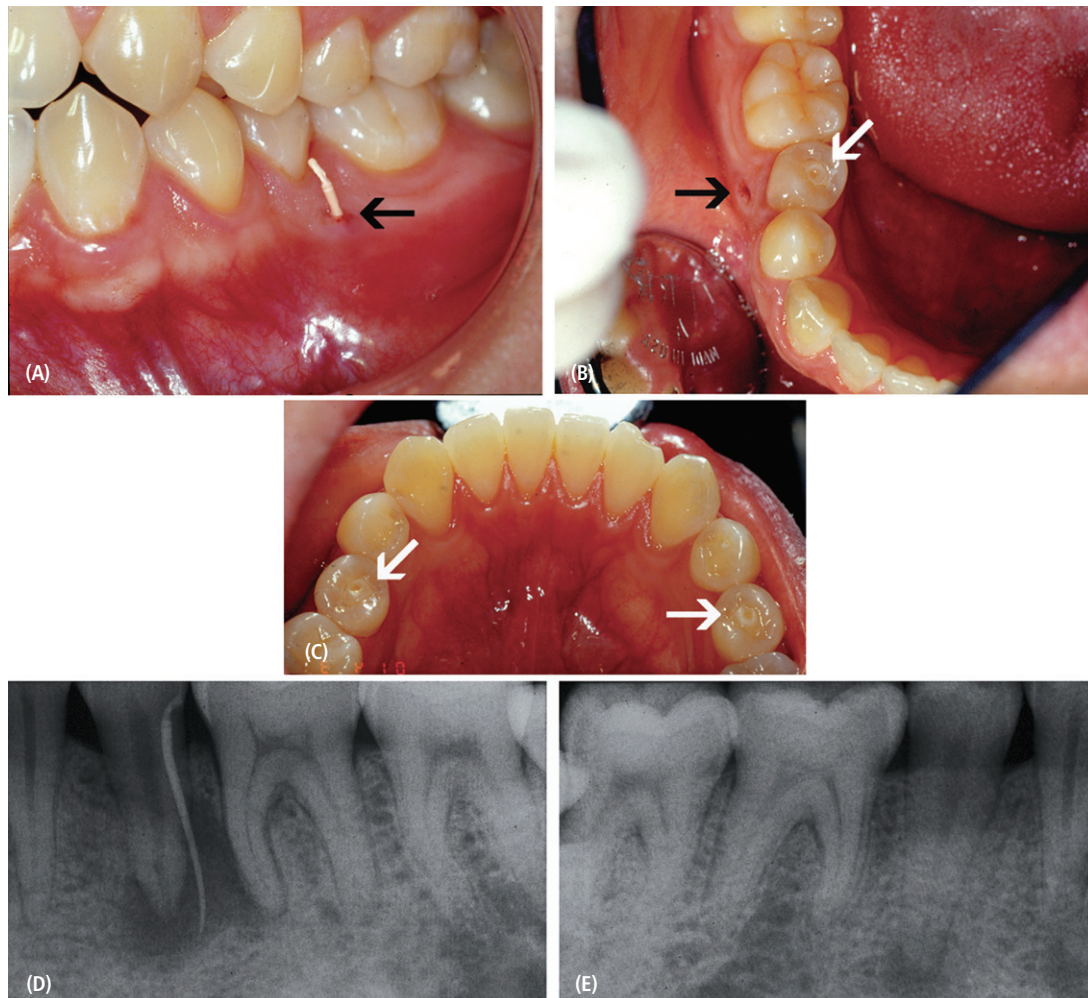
A. Buccal view of the pre-operative clinical presentation of the sinus tract (black arrow) of tooth 20 with a gutta percha inserted. B. Occlusal view of the pre-operative clinical presentation of the dens evaginatus (white arrow) and the sinus tract (black arrow) of tooth 20. C. Occlusal view of the preoperative clinical presentation of bilateral dens evaginatus (white arrows) on teeth 20 (right) and 21 (left). D. Pre-operative PA radiograph of tooth 20. E. Pre-operative PA radiograph of tooth 29.
